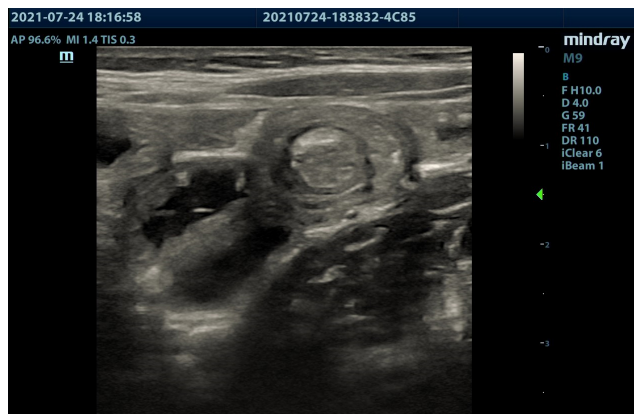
Color ultrasound showed a heterogeneous mass
